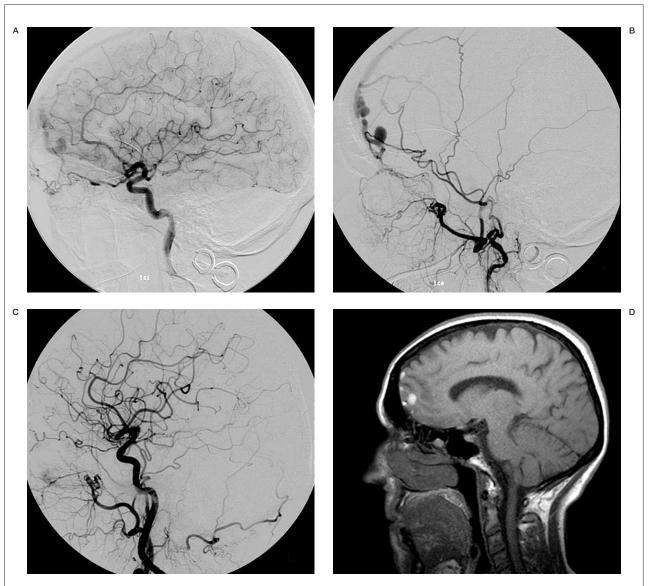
A 63-year old woman presenting with an incidental finding of an anterior fossa DAVF. Lateral left internal (A) and external (B) carotid artery angiogram reveals a DAVF supplied by dural ethmoidal branches from both ophthalmic arteries and also from dural branches from the external carotis arteries (mainly the anterior middle meningeal and anterior ethmoidal arteries), with a small nidus and direct filling of a dilated osteodural left frontal vein with several venous ectasias. Control angiogram (C) several weeks after the initial diagnostic DSA demonstrates the occlusion of the anterior fossa DAVF. MR imaging (D) confirms the thrombosis of the single draining cortical vein on sagittal T1 weighted images.
